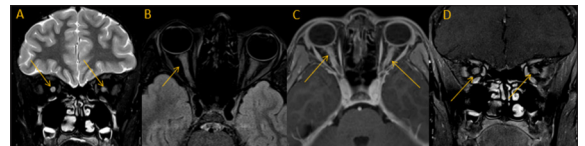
Coronal T2 STIR (A), axial T2 FLAIR (B), axial contrast-enhanced T1-weighted fat-suppressed (C) and coronal contrast-enhanced T1-weighted fat-suppressed (D) images showing increased T2 signal, mild enlargement and bilateral post-contrast enhancement of the retrobulbar segments of the optic nerves.
